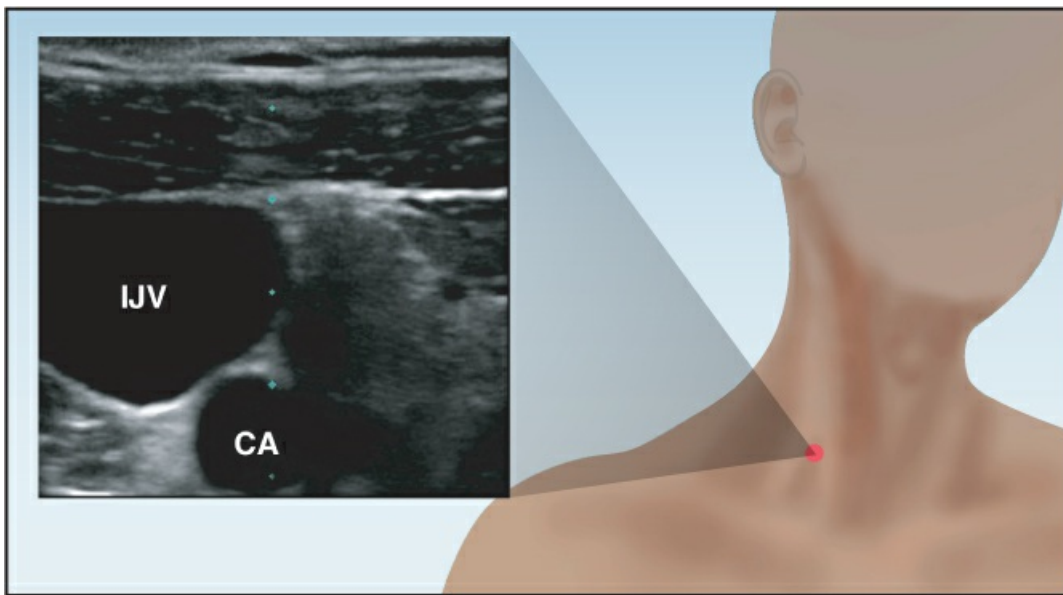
Short-axis view of the internal jugular vein (IJV) and carotid artery (CA), obtained by placing the ultrasound probe at the apex of the triangle formed by the two heads of the sternocleidomastoid muscle. The green dot marks the lateral side of the image. See text for further explanation.
